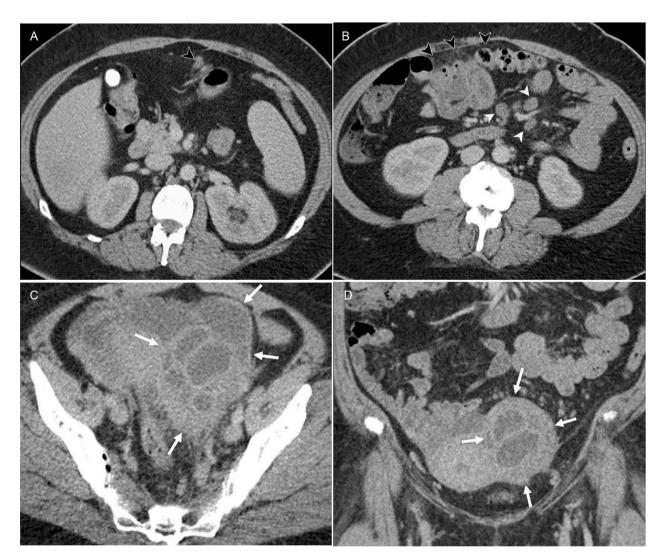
38-year-old female with ovarian mass. Axial (A, B, and C), and (D) coronal post-contrast CT images of the abdomen and pelvis demonstrate a complex, multiloculated, left adnexal cystic and solid mass with surrounding inflammatory changes (white arrows). Studding and nodularity of the greater omentum was also present (black arrows). Enlarged mesenteric lymph nodes were also seen throughout the abdomen (white arrowheads).
